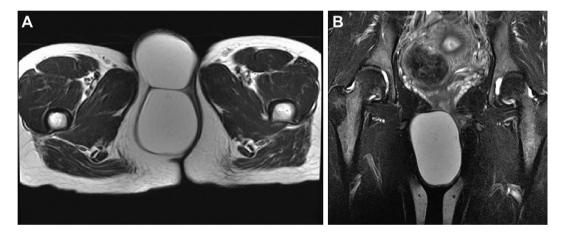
Axial (A) and coronal (B) T2-weighted images show a 12 cm \times 9 cm \times 6 cm, well defined, septated cystic mass in the subcutaneous tissue of the right labia majora. The mass had high T2-weighted signal intensity without contrast enhancement.
